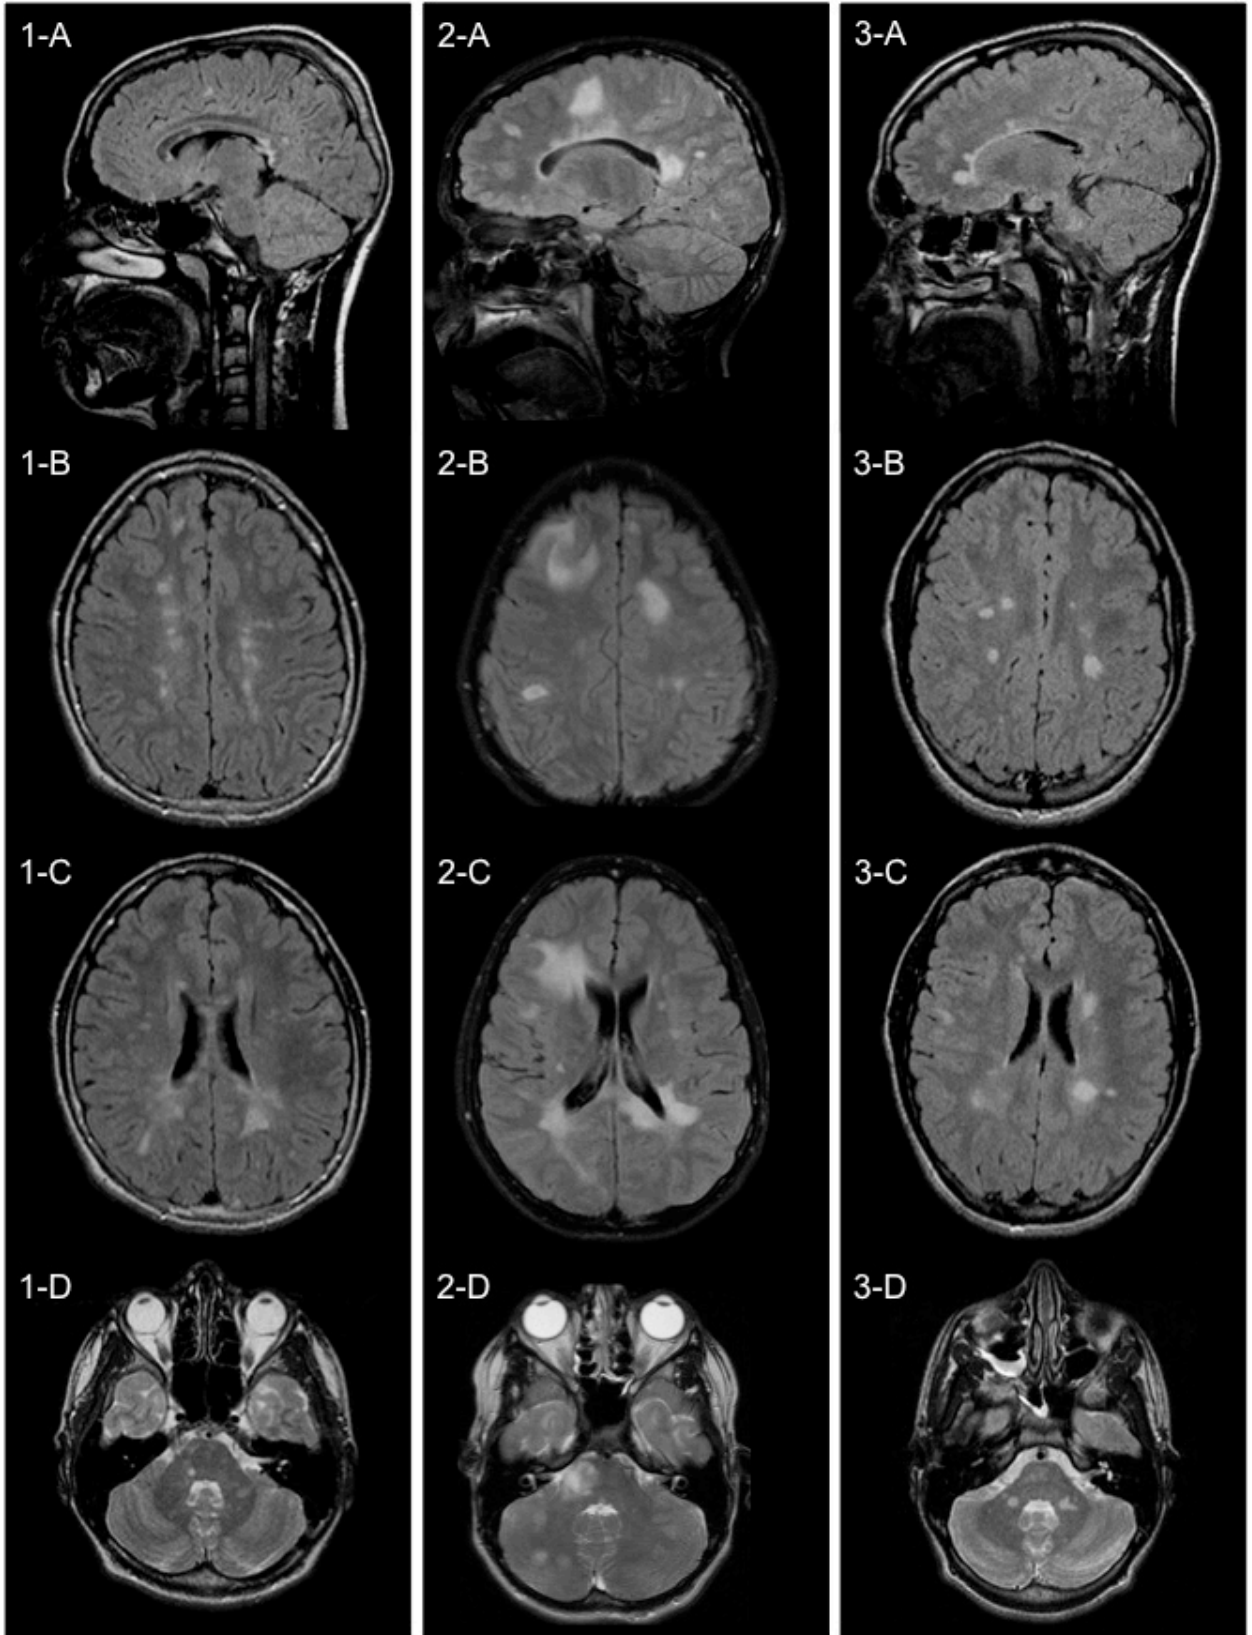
MRI features of children with MS. Sagittal (row A) and axial (rows B and C) FLAIR and axial T2-weighted (row D) images of children with MS. All children were more than 10 years of age at the time of first demyelinating attack. Images acquired four months after onset (Column 1) and at the time of onset (Column 2) are presented from two boys, both of whom presented with polyfocal neurological deficits, without encephalopathy. Column 3 contains images acquired from a boy six months after presentation with brainstem symptoms.
